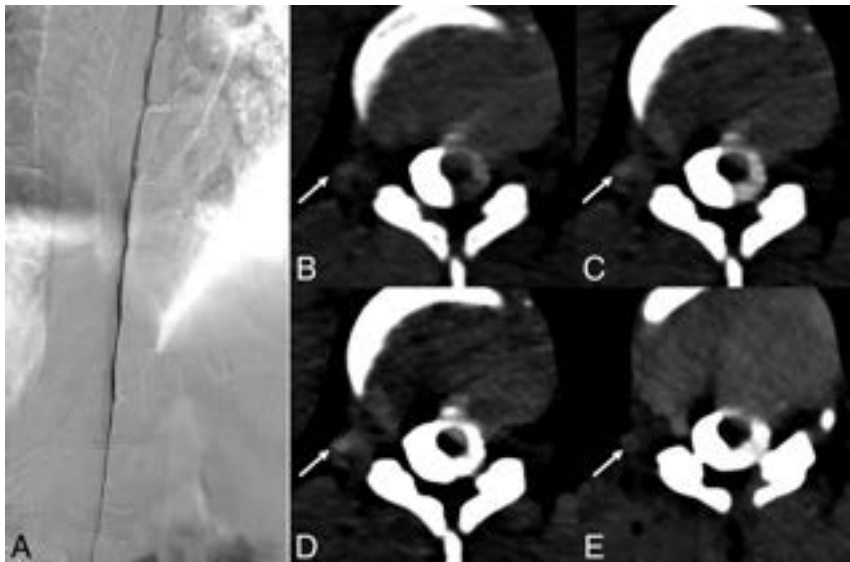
A 36-year-old woman with several years of orthostatic headaches, tinnitus, and MR imaging demonstrating brain sag without pachymeningeal enhancement (not shown). A representative image from a right lateral decubitus DSM (A) shows no evidence of a CVF. Axial images from a right lateral decubitus PCD CTM at the same time point (B–D) reconstructed at a T3D (B), 55 keV (C), and 40 keV (D) demonstrate a subtle right T1 CVF (B–D, *arrows*), most apparent at 40 keV. An axial 40-keV image obtained 20 seconds later (E) no longer shows this subtle venous opacification (E, *arrow*). The patient underwent Onyx embolization of this right T1 fistula.
